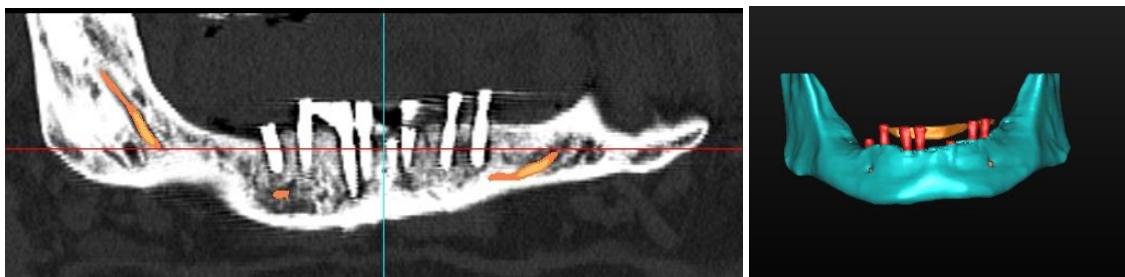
Mandibular implants connected with a connecting bar (CT scan view)
